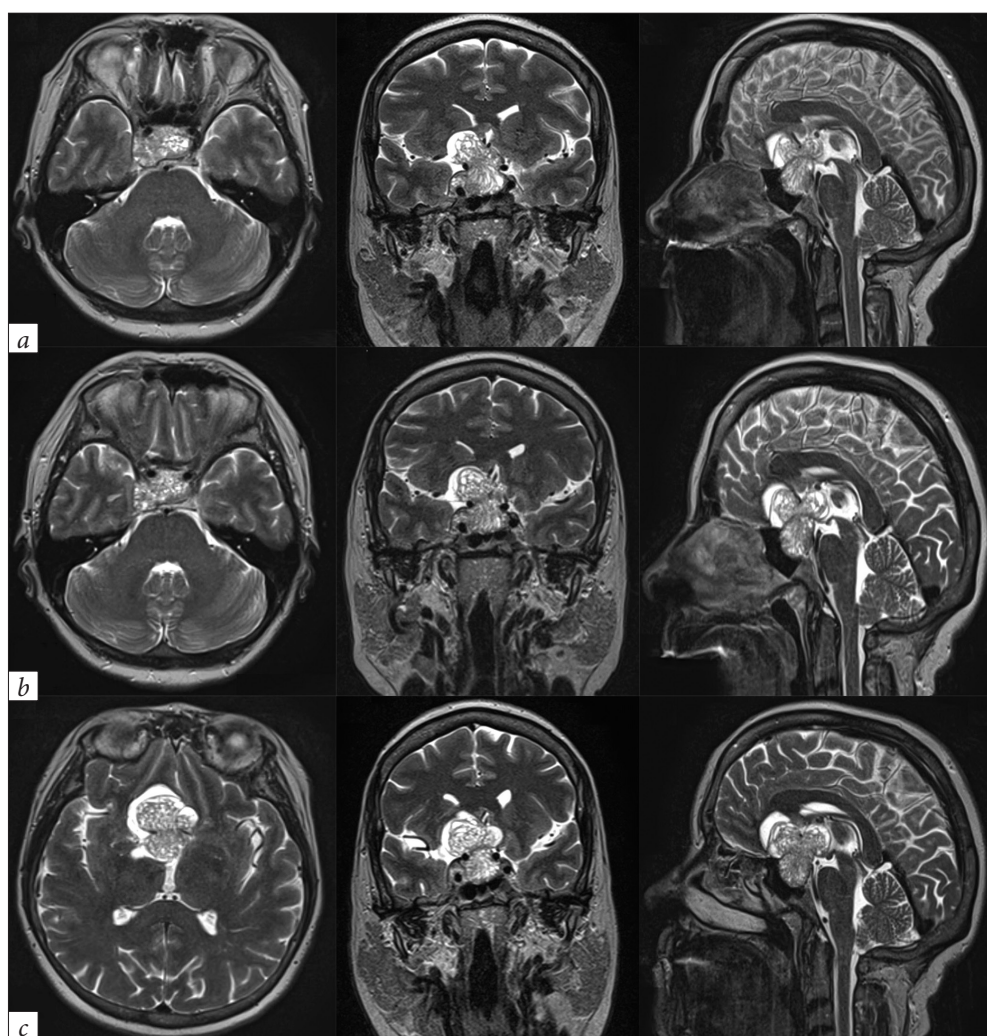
Series of axial, coronal, and sagittal MR images. (a) December 2018. Non-enhanced T2-weighted MRI demonstrating almost unchanged size of adenoma compared to the previous survey ($37 \times 32 \times 29$ mm). (b) December 2019. Non-enhanced T2-weighted MRI. Compared to survey of December 2018, no significant dynamics were found ($37.5 \times 32 \times 29$ mm). (c) December 2020. Non-enhanced T2-weighted MRI showing a giant pituitary adenoma ($48 \times 37 \times 31$ mm). Compared with the previous MRI data, the tumor's volume increased by 6.5%
